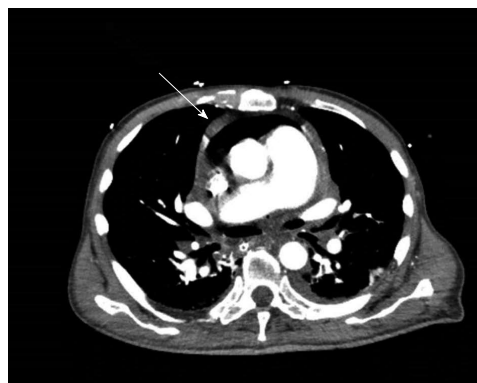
Computed tomography axial section at thoracic level revealing pneumopericardium, as denoted by arrow.
